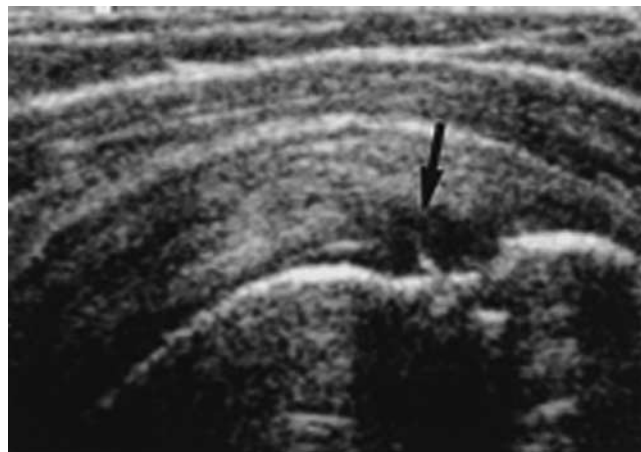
Ultrasonographic image showing a small hypoechoic tendon tear, located on the deep articular side of the rotator cuff (arrow). The image is oriented in a plane parallel to the longitudinal axis of the tendon. Reprinted with permission from Teefey et al.⁹⁴
